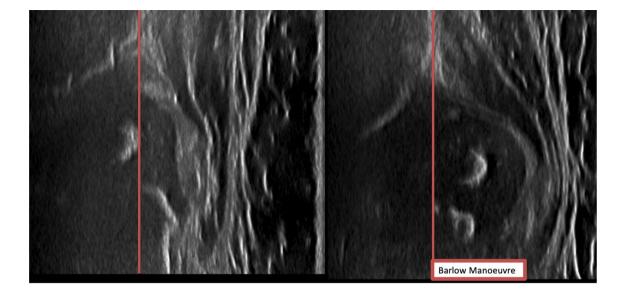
Ultrasound image showing a Barlow positive hip subluxating
